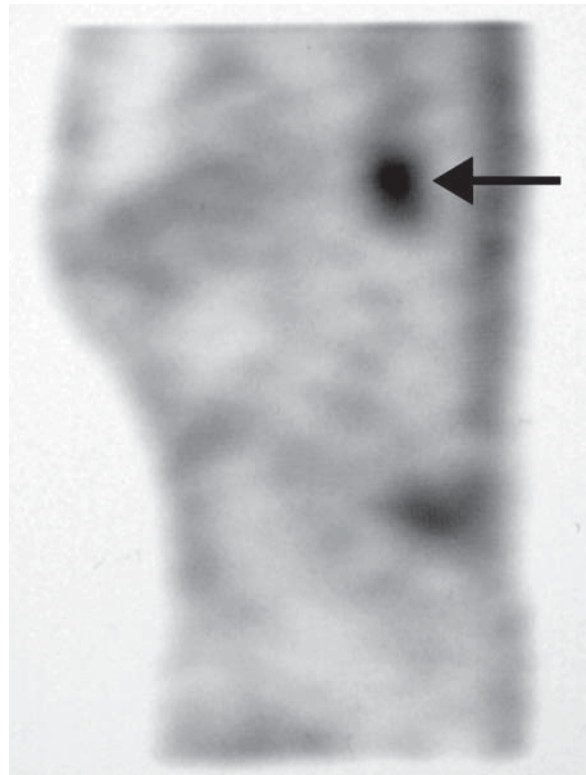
Vertebral body osteomyelitis with discitis. The SPECT gallium scan shows involvement of both vertebral body endplates and the disc (*arrow*) despite the negative MRI (Fig. 4).
